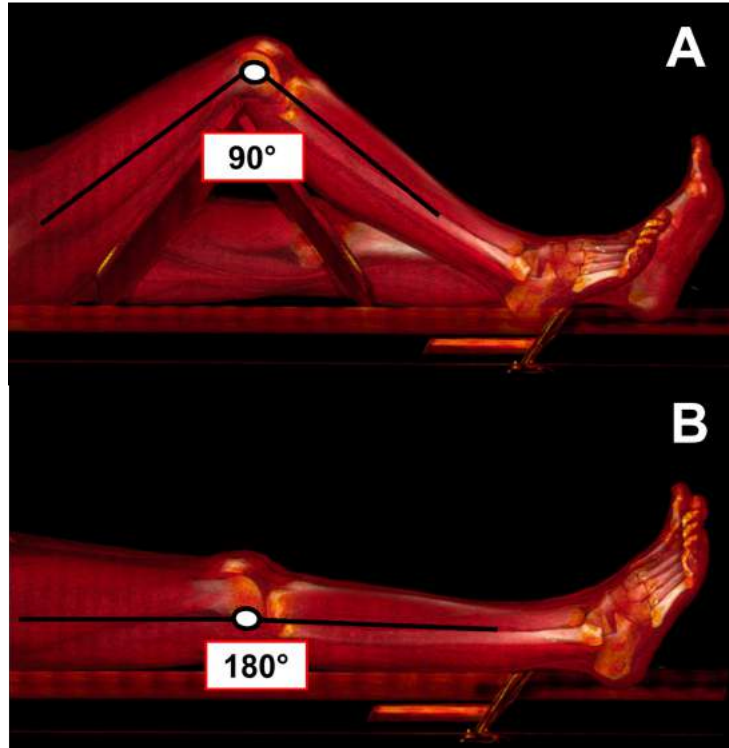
CTA acquisition in standardized (A) bent-leg and (B) straight-leg positions.
